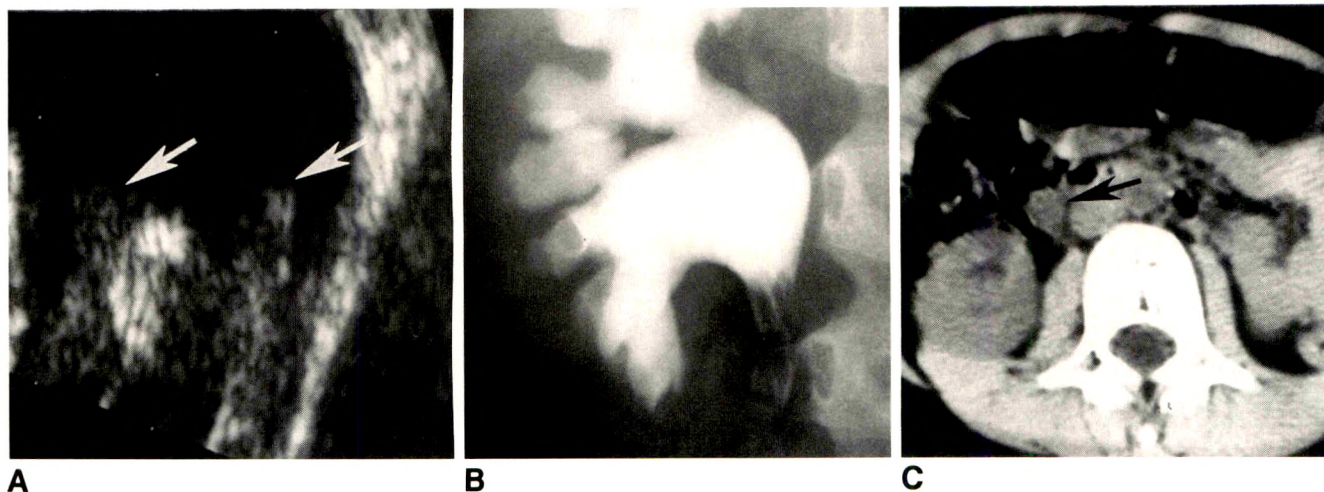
A, Coronal sonogram (rotated to align with B) shows soft-tissue fronds (arrows) floating in renal pelvis. There is no shadowing to suggest calculus.
